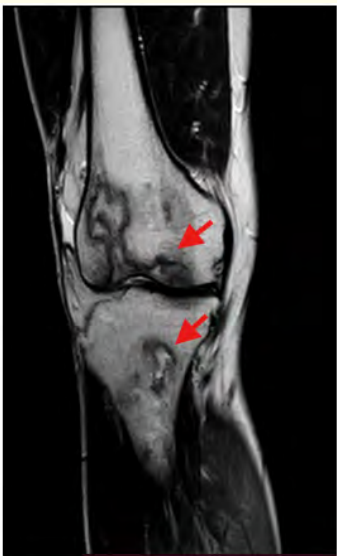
Coronal T2-weighted image of the patient’s right knee showing osteonecrosis.
